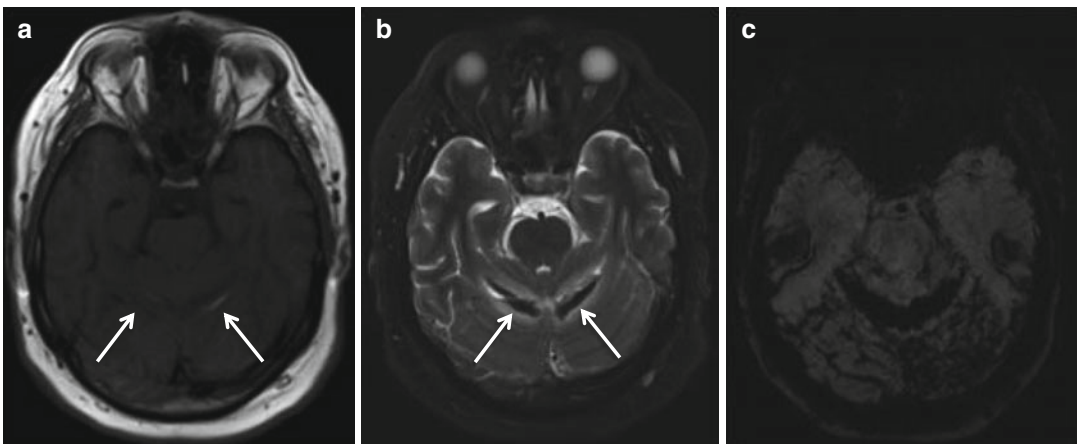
Remote cerebellar hemorrhage post-craniotomy. (a–c) Non-enhanced CT depicts blood with curvilinear stripe appearance called “zebra sign” in the cerebellum.
